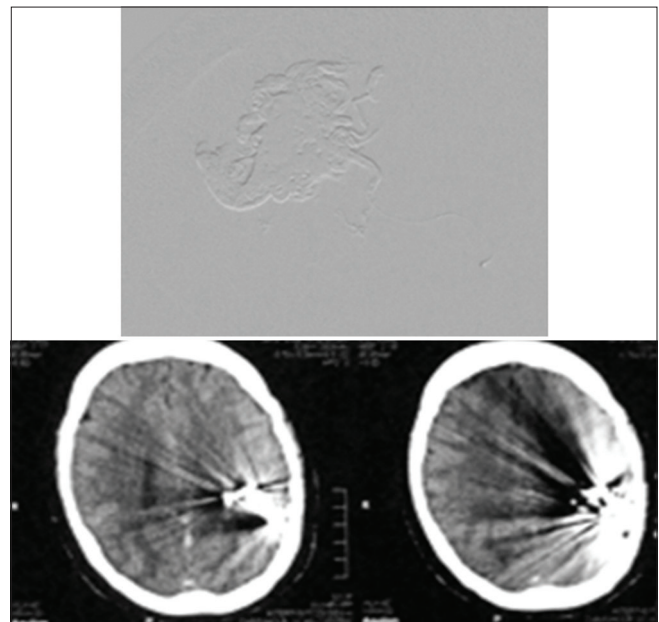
Demonstration of Onyx cast and follow-up computed tomography brain showing complete obliteration
